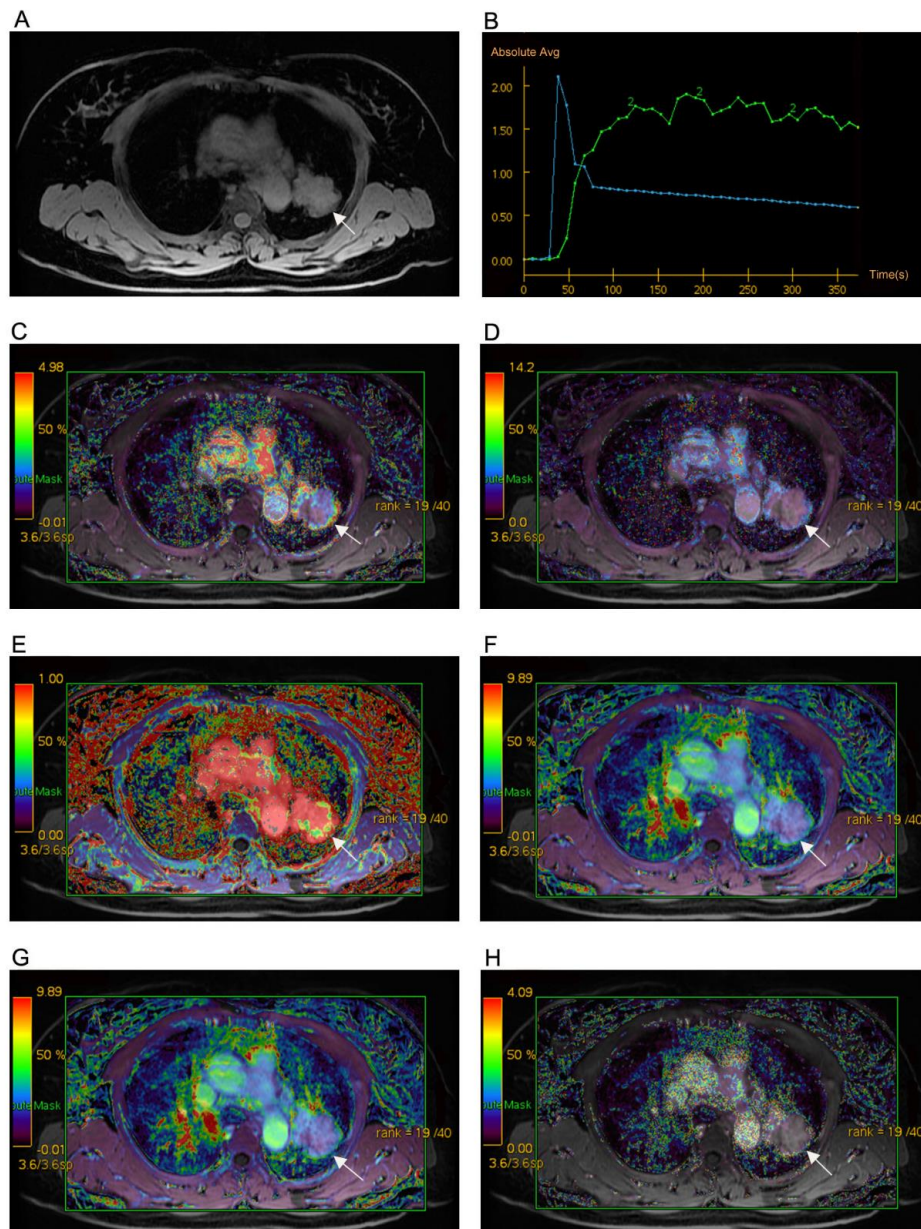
DCE-MRI parameters obtained during the diagnosis of a patient with left upper lung adenocarcinoma. The determined DCE-MRI parameters: (A). T1-weighted, (B). time-concentration curve, (C). pseudo-color map of Ktrans, (D). pseudo-color map of Kep, (E). pseudo-color map of Ve, (F). pseudo-color map of CER, (G). pseudo-color map of IAUGC, (H). pseudo-color map of MaxSlope.
